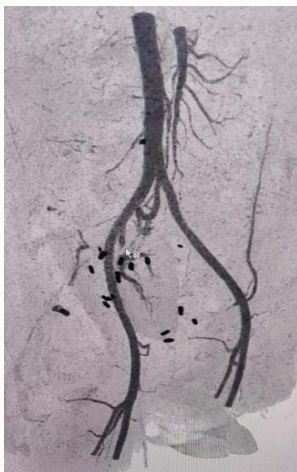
Preoperative CT Angio showing filling defect in graft renal artery.
